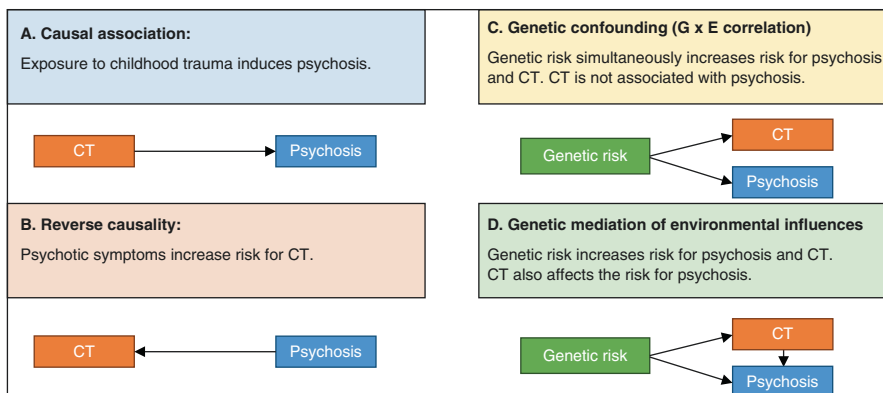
Etiological models explaining the association between childhood trauma (CT) and psychosis [28]
